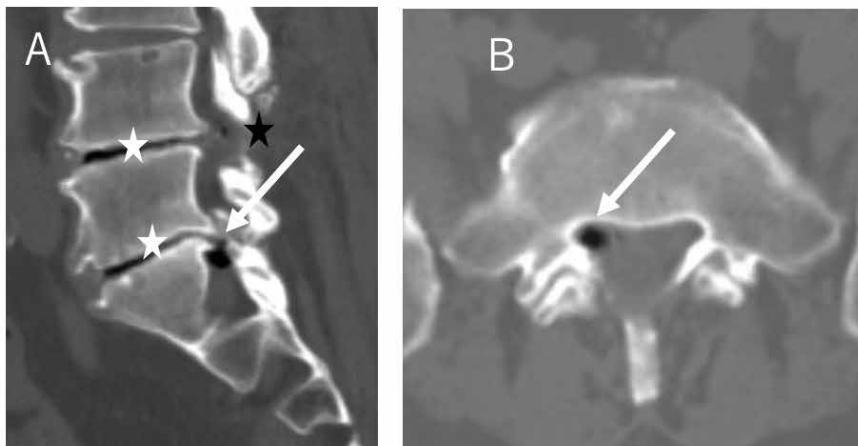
Computed tomography scans obtained before surgery. (A) shows the vacuum phenomenon in the disc space (white stars) and both small (black star) and large (arrow) collections of epidural gas at L5–S1. (B) Axial computed tomography scan through the S1 endplate clearly reveals epidural gas at the right lateral recess near the S1 nerve root.
